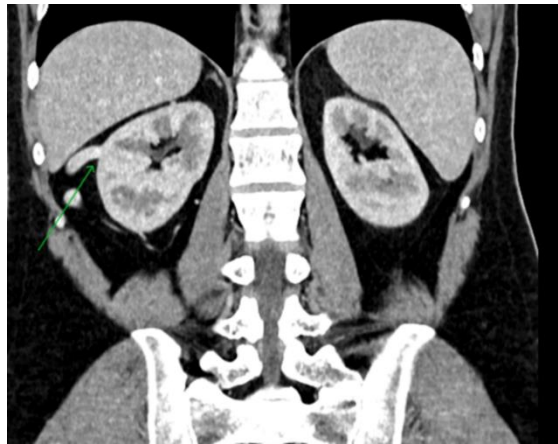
Coronal CT depicting the cranial capsular segment of the cortical collateral (arrow)
